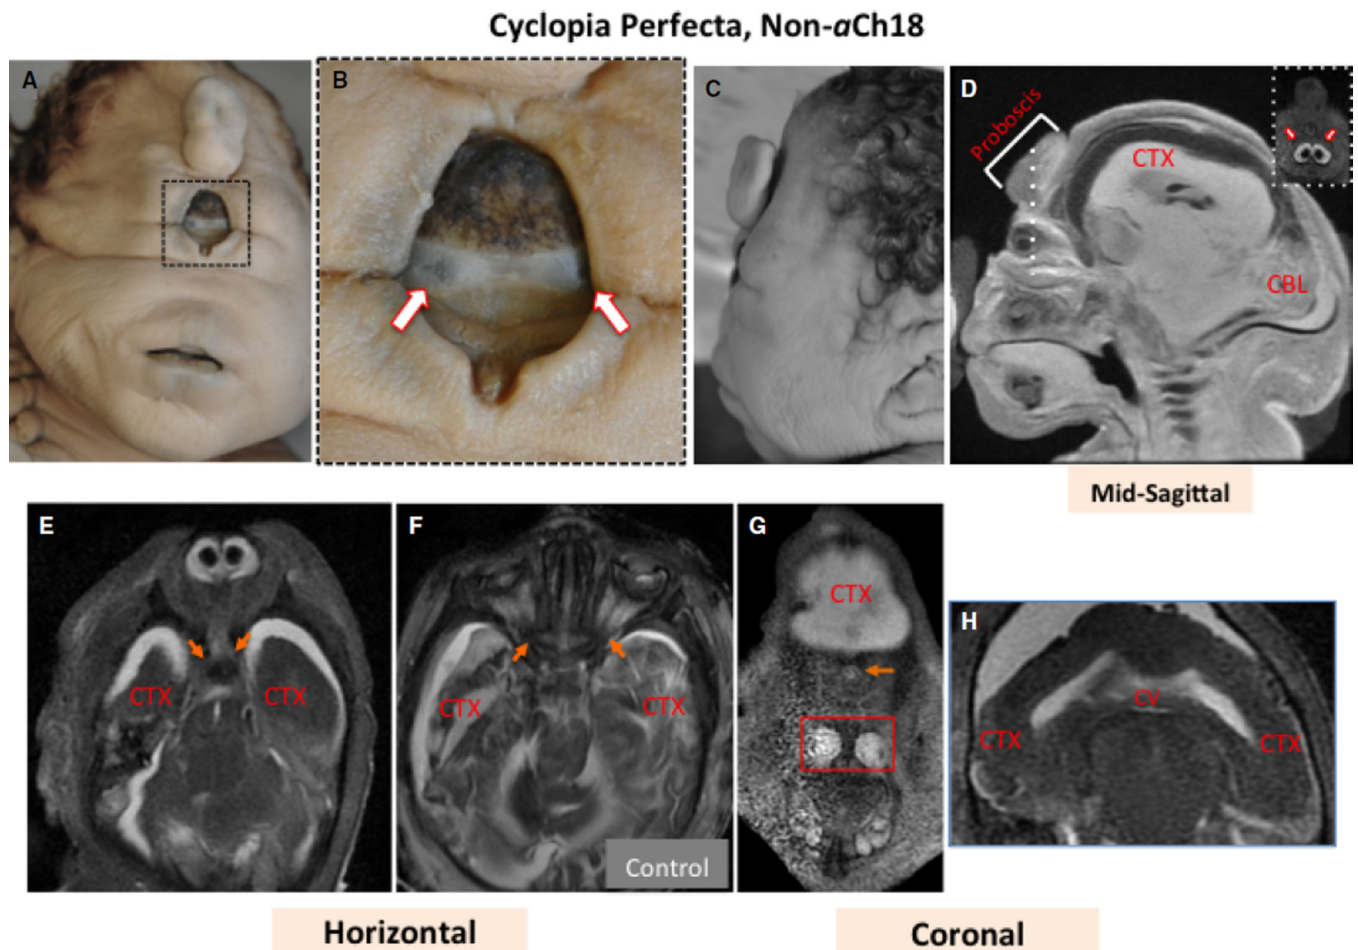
Superficial and MRI analysis of craniofacial features of a 35-week non-aberrant Ch18 (α Ch18) cyclopic fetus with normal karyotype. (A, B) Frontal views of the 35-week cyclops with (B) enlargement of the eye to reveal two globes (arrows). (C) A lateral view of the head. (D) Sagittal, (E) horizontal, and (G and H) coronal sections through the head and face. (F) Age-matched control. The dashed line in (D) shows the plane of inset at the right. Arrows in (E) show bifurcating nerves as they enter the brain laterally. Arrows in (F) show nerves originating from two optic globes for normal binocular vision. The arrow in (G) shows a single optic nerve centrally, and the box reveals nasomaxillary structures. (H) A single cerebral ventricle (CV) in white connected at the midline, and unseparated cerebral cortex (CTX). CTX appears dark or light depending on if the images were, respectively, acquired with T1 or T2 weighting.
